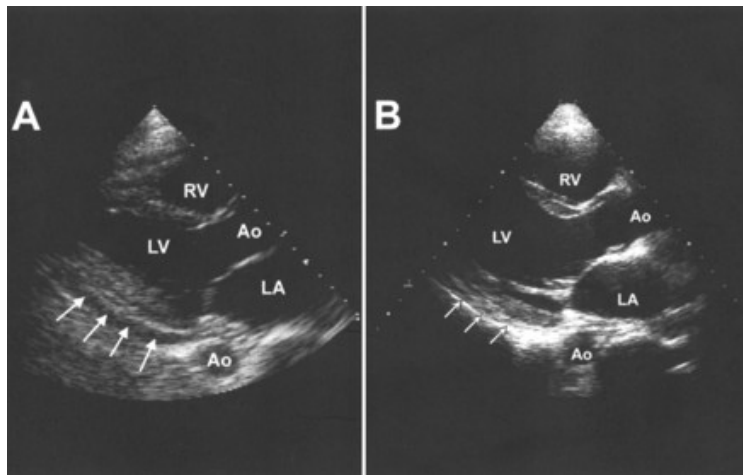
(A) Echocardiographic findings in constrictive pericarditis. Parasternal long-axis view of a 39-year-old man who presented one month after a motor vehicle accident with dyspnea, showing markedly increased pericardial thickness (arrows). (B) Follow-up echocardiogram performed one month later, showing near-normal pericardial thickness (arrows). Ao = aorta; LA = left atrium; LV = left ventricle; RV = right ventricle.
